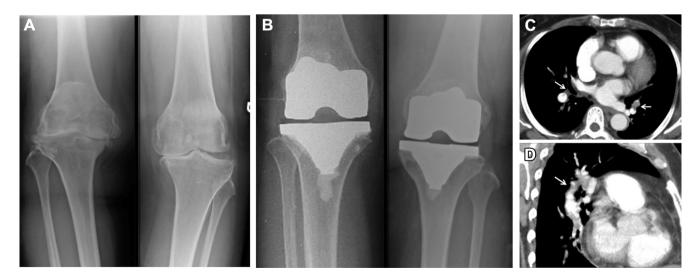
Patient 4, a 76-year-old woman. (A) Plain film radiograph showing bilateral advanced osteoarthritis of the knee. (B) Plain film radiograph bilateral total knee replacements. (C) Axial computed tomography pulmonary angiogram showing pulmonary embolus affecting several segmental pulmonary arteries of the left lung. (D) Oblique sagittal reformations of computed tomography pulmonary angiogram showing pulmonary embolus affecting several segmental pulmonary arteries of the left lung.
